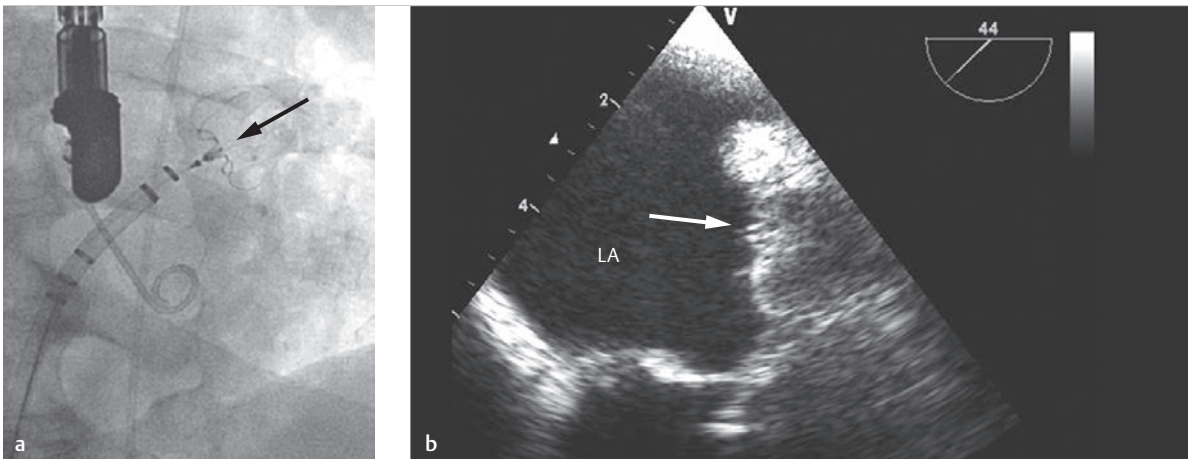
Combination of angiography, X-ray, and CT with echocardiographical methods. Simultaneous angiographic and echo depictions of a Watchman closure device in the left auricle of a male patient with chronic atrial flutter and contraindication against oral anticoagulants.
